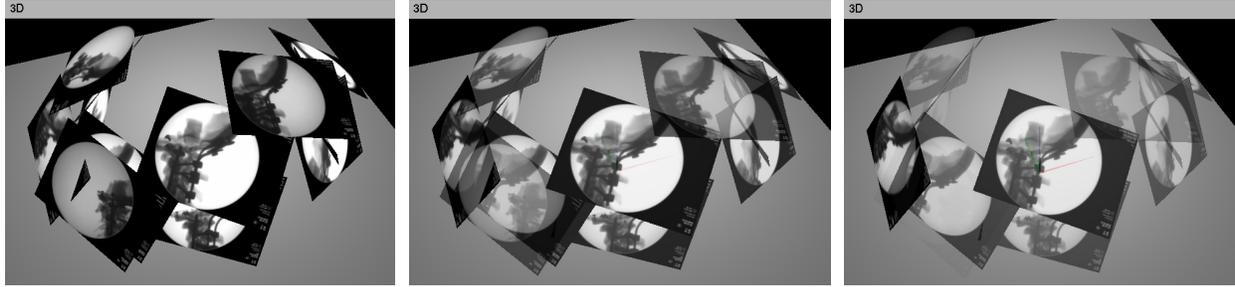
The spatial 3D arrangement also provides temporal cues with transparency mapping. The user can interactively control the mapping through a slider to make all X-rays fully opaque (left), or fade out older ones (right).
